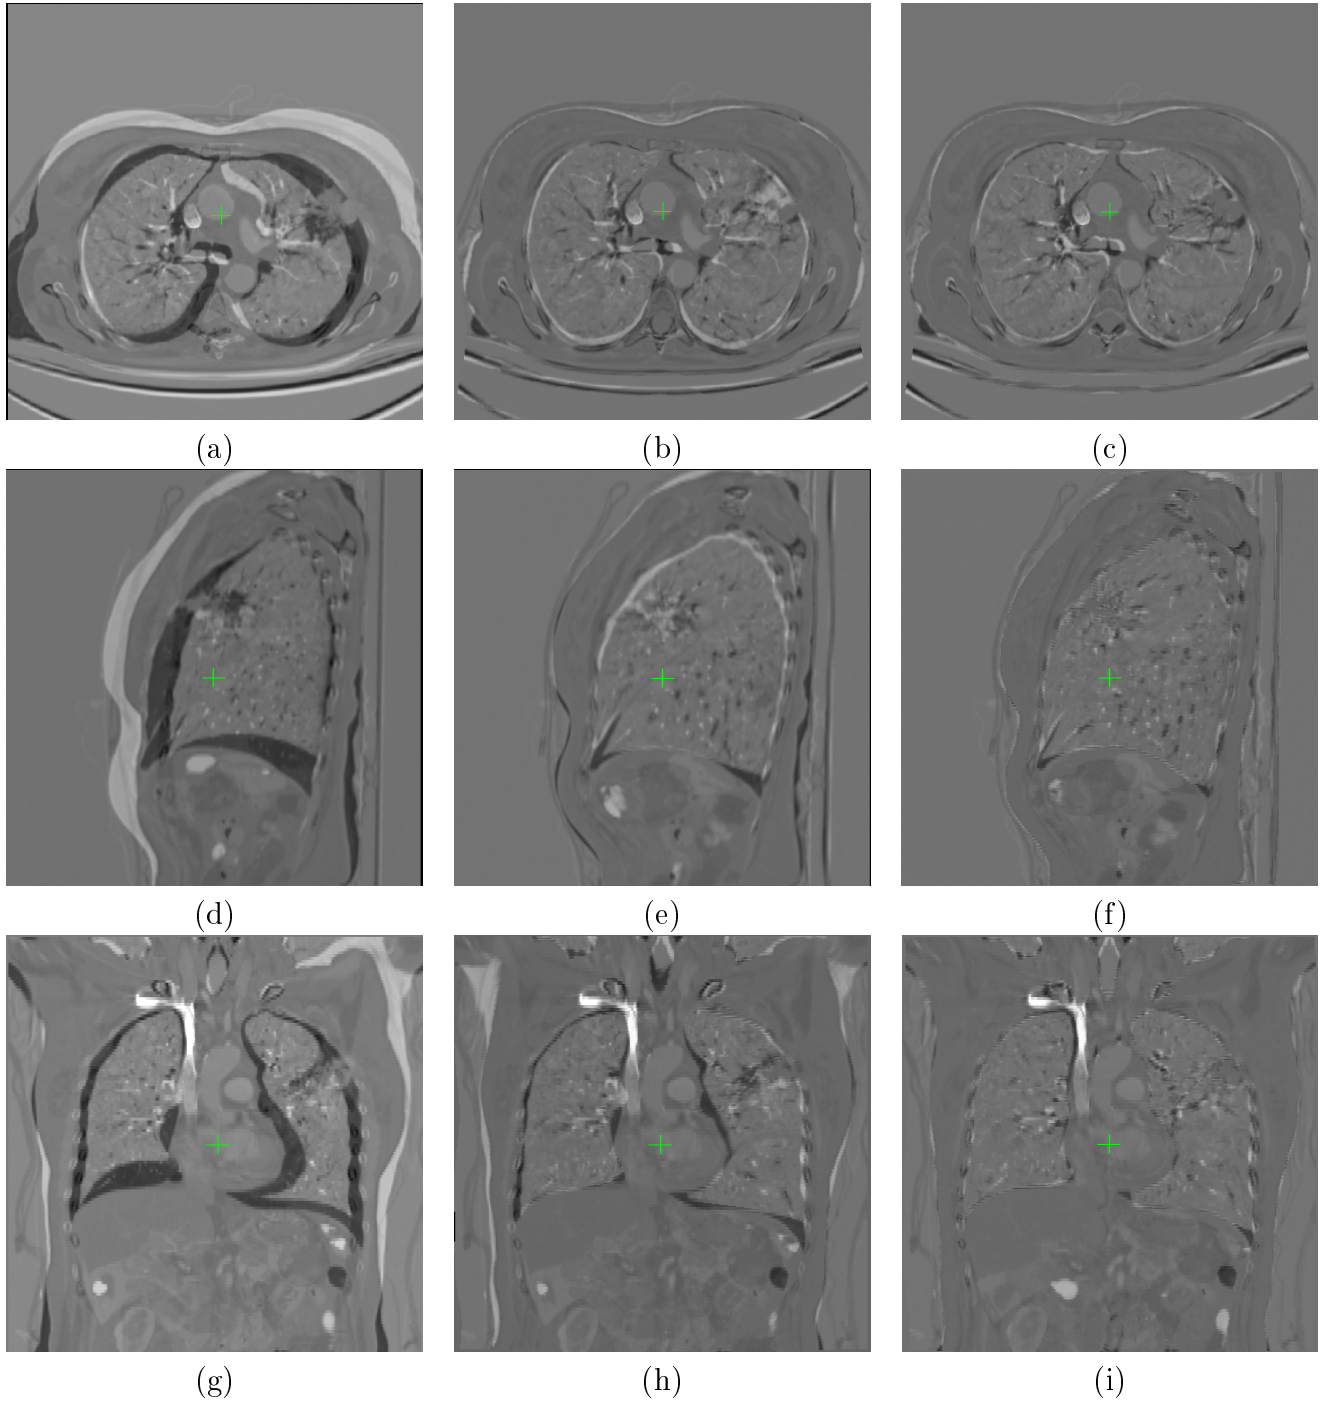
Three orthogonal views of difference images between diagnostic CT and AC-CT images (Patient 1): First column (a), (d) and (g) without registration. Second column (b), (e) and (h) results using classic fluid registration. Third column (c), (f) and (i) results using our proposed method.
